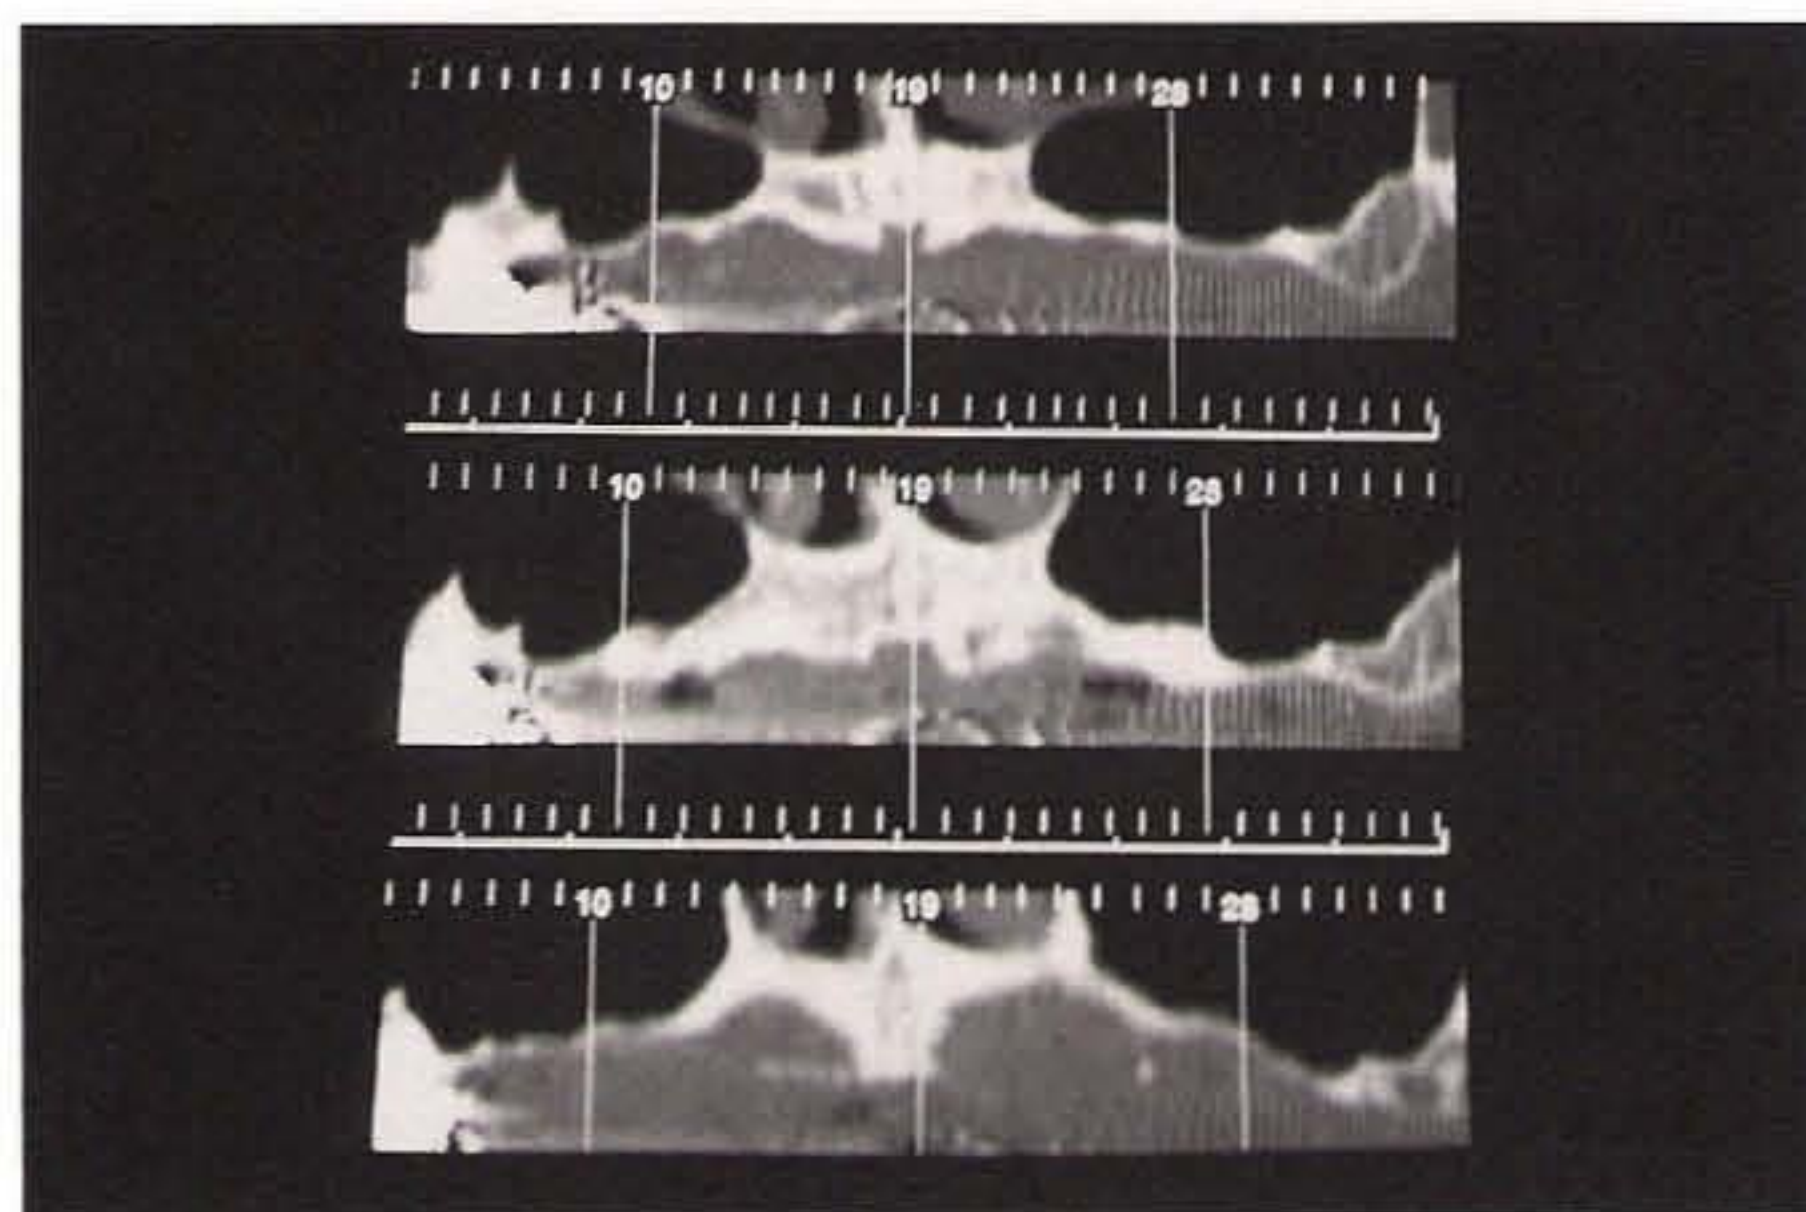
The CT scan indicates that atrophy is also extensive in the distal area of the maxilla.
